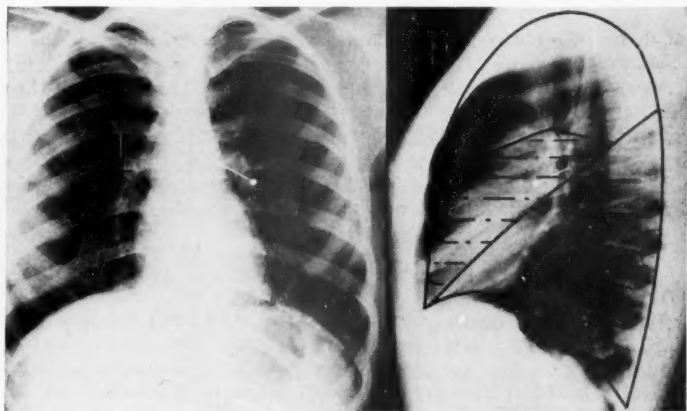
Foreign body (shawl pin) shown by lateral roentgenogram to be located in the inferior segmental branch of lower division of left upper lobe bronchus. This foreign body was removed by fluoroscopically guided bronchoscopy.
